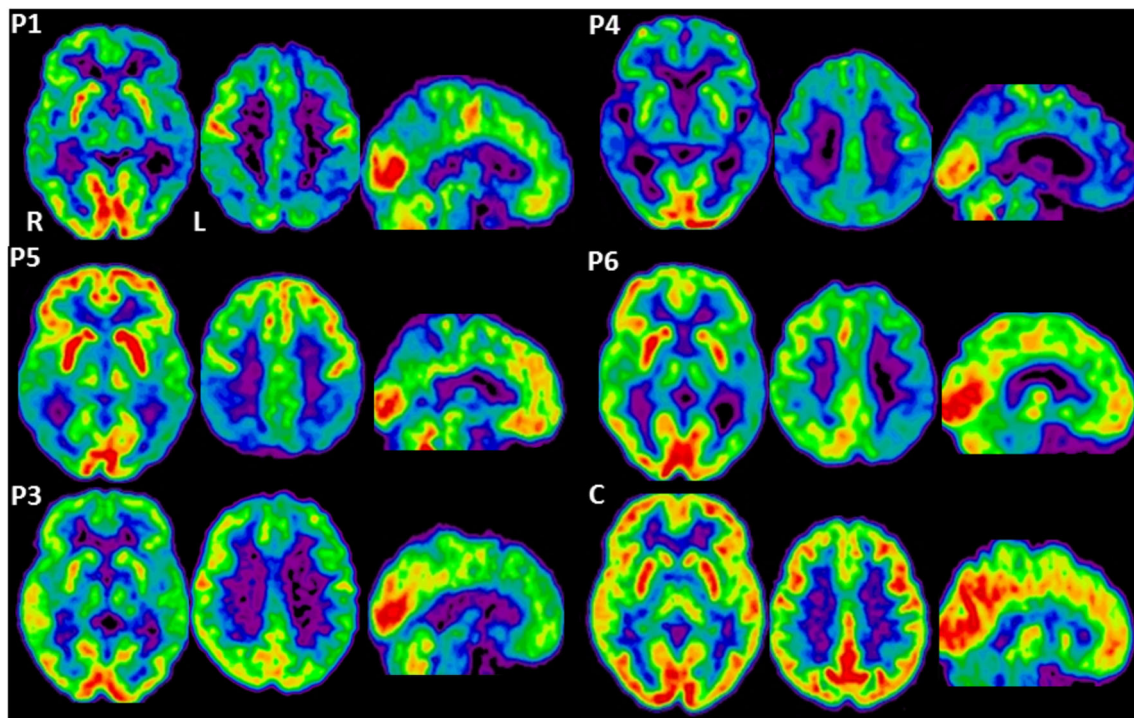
PET transaxial images at two axial and one sagittal section show ^{18}F FDG uptake in the patients (P1, P4, P5, P6, P3) and in a control subject (C). Compared with control, P1, P4, and P5 showed a relative hypometabolism involving mainly the posterior cortical regions
